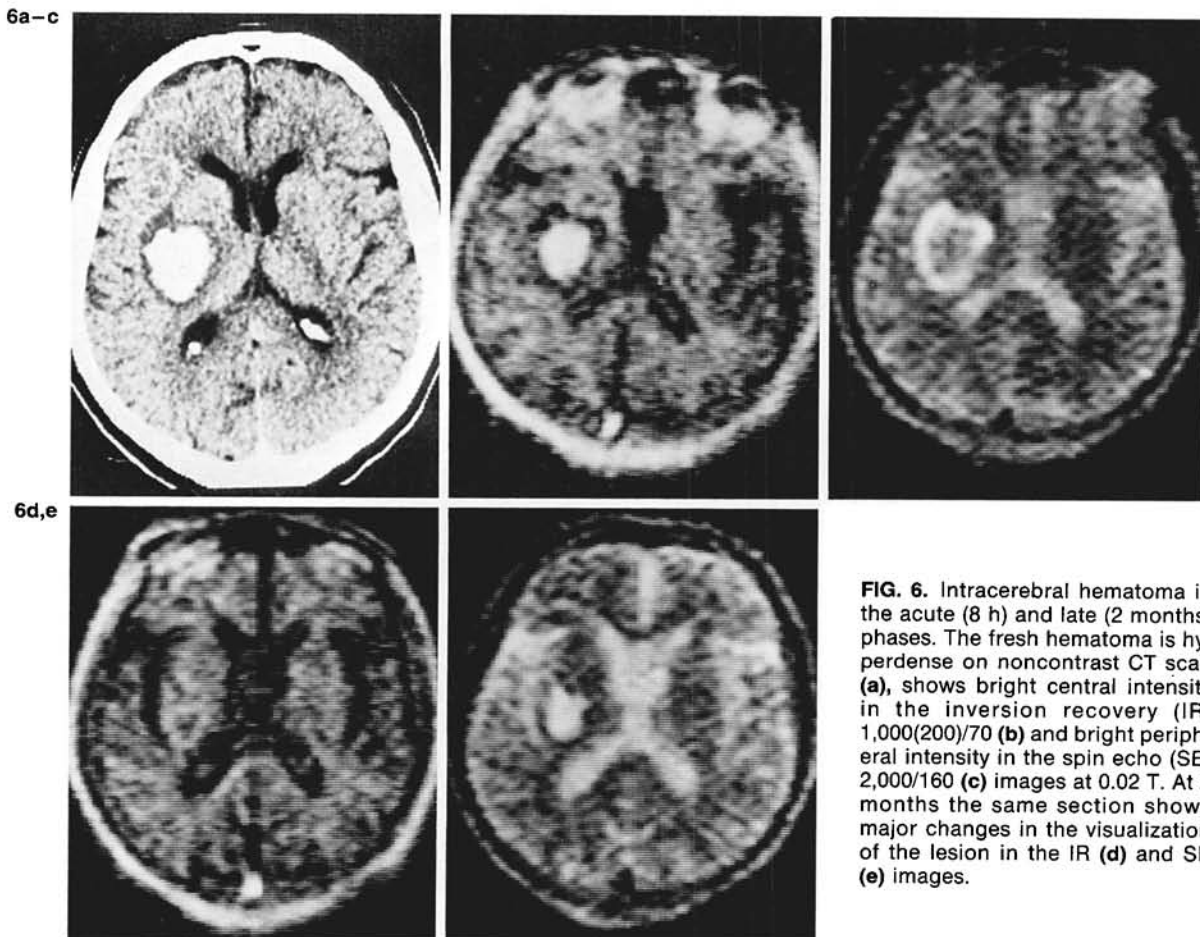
Intracerebral hematoma in the acute (8 h) and late (2 months) phases. The fresh hematoma is hyperdense on noncontrast CT scan (a), shows bright central intensity in the inversion recovery (IR) 1,000(200)/70 (b) and bright peripheral intensity in the spin echo (SE) 2,000/160 (c) images at 0.02 T. At 2 months the same section shows major changes in the visualization of the lesion in the IR (d) and SE (e) images.
